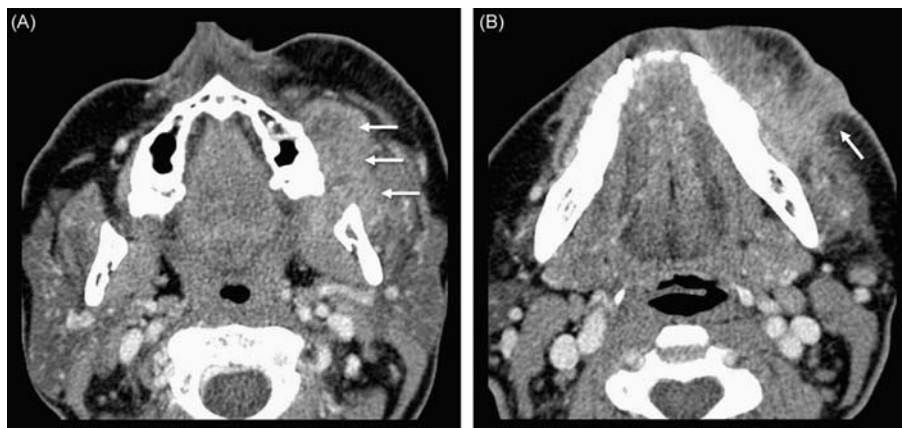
Squamous cell carcinoma of the left buccal mucosa, T4a. (A) Axial contrast-enhanced CT shows large left buccal mass (arrows) extending to maxillary RMT. (B) Axial contrast-enhanced CT (inferior to A) shows inferior and lateral extension to involve the skin (arrow). Involvement of the skin is critical to note, because the tumor is upstaged to T4a. From Aiken, A. H. (2013). Pitfalls in the staging of cancer of oral cavity cancer. *Neuroimaging Clinics of North America* 23(1), 27–45.
